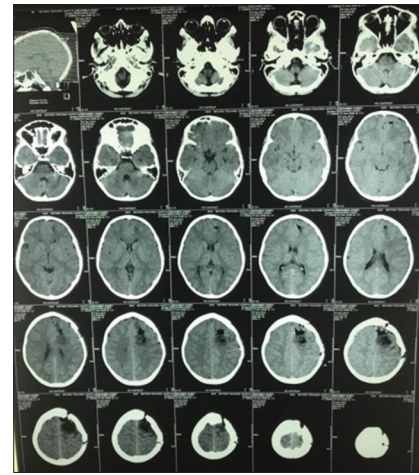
One-week postoperative computed tomography brain.
